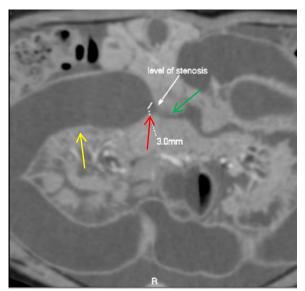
CT-scan of the abdomen without coronal contrast shows obstruction of the ileum (red arrow) with dilatation in the proximal segment (yellow arrow) and collapse in the distal segment (green arrow) of the obstruction.
